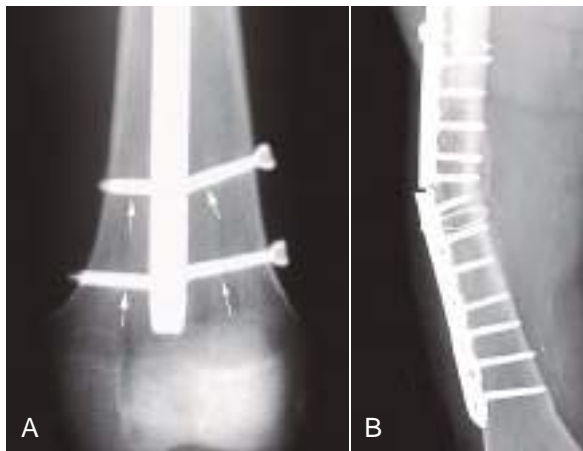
Hardware failure. (A) AP radiograph in a patient with a femoral shaft fracture that was fixed with an interlocking intramedullary nail. He resumed weight-bearing earlier than advised, which placed shearing force across the interlocking screws. The distal screws failed (*arrows*). (B) Hardware fracture. Failed fixation of proximal femur fracture with compression plate and screws.
